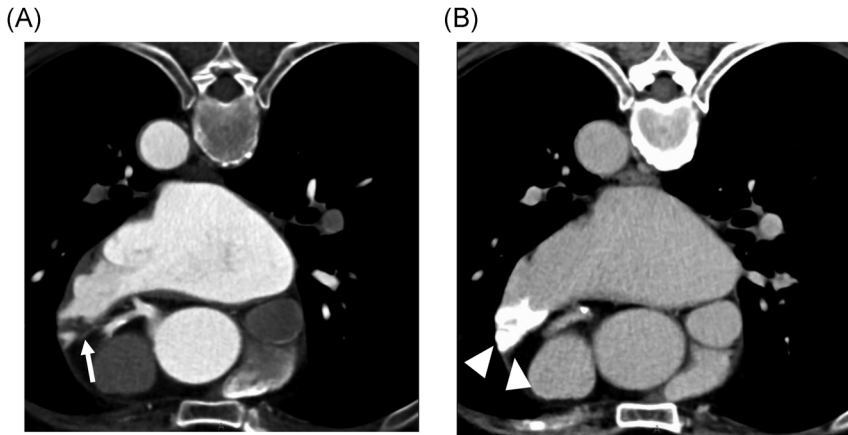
Difference in the contrast defects (CDs) on computed tomography between the early and late phases
